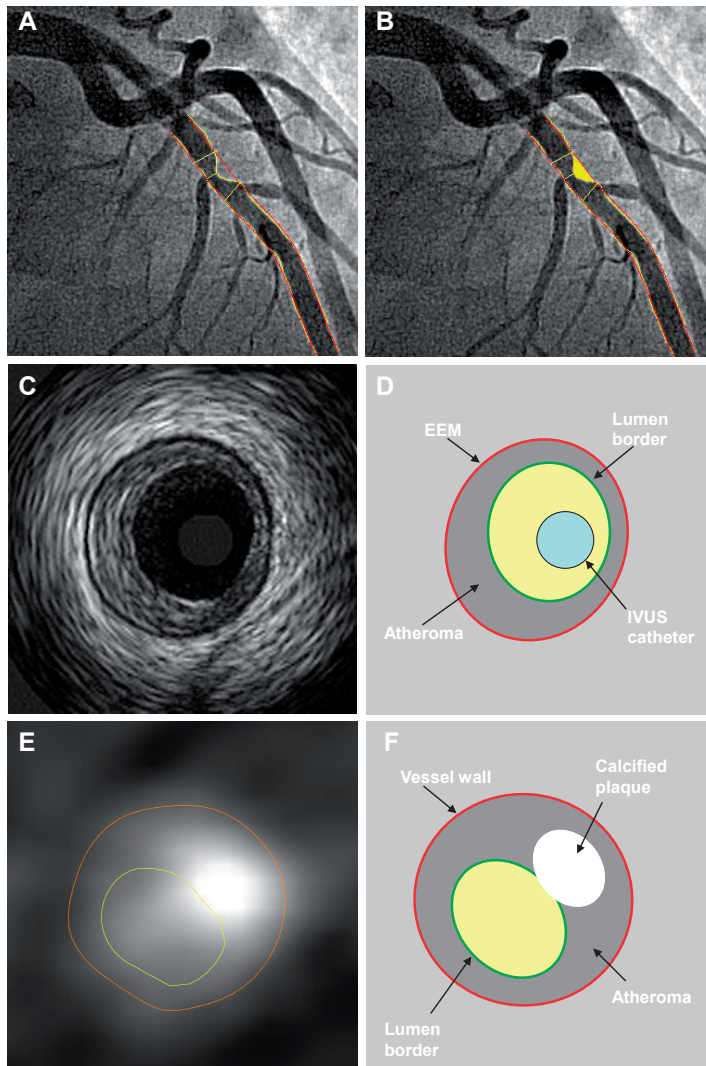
Difference in coronary plaque assessment between IVUS , invasive coronary angiography (ICA) and quantitative computed tomography coronary angiography (QCT).
